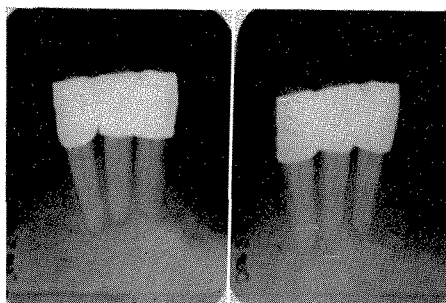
Roentgenograms of the lower incisors taken in 1960. There had been no change up to the time the roentgenograms were taken.
